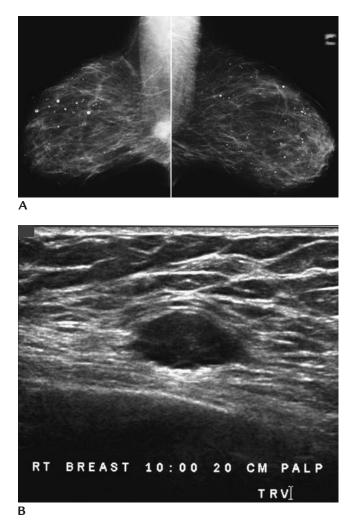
Invasive ductal carcinoma, poorly differentiated. (A) A mass with indistinct margins is partially imaged superimposed on the lower most aspect of the right pectoral muscle. Multiple attempts to image the lesion in the craniocaudal projection were unsuccessful. Multiple lucent centered calcifications are present diffusely scattered bilaterally. (B) An oval hypoechoic mass with microlobulated and spiculated margins and some posterior acoustic enhancement is imaged corresponding to the mass seen mammographically. Although the patient reportedly had a normal physical examination prior to her screening mammogram, this mass is palpable, hard but movable. Ultrasound is helpful in evaluating areas that may otherwise be difficult to image mammographically.
